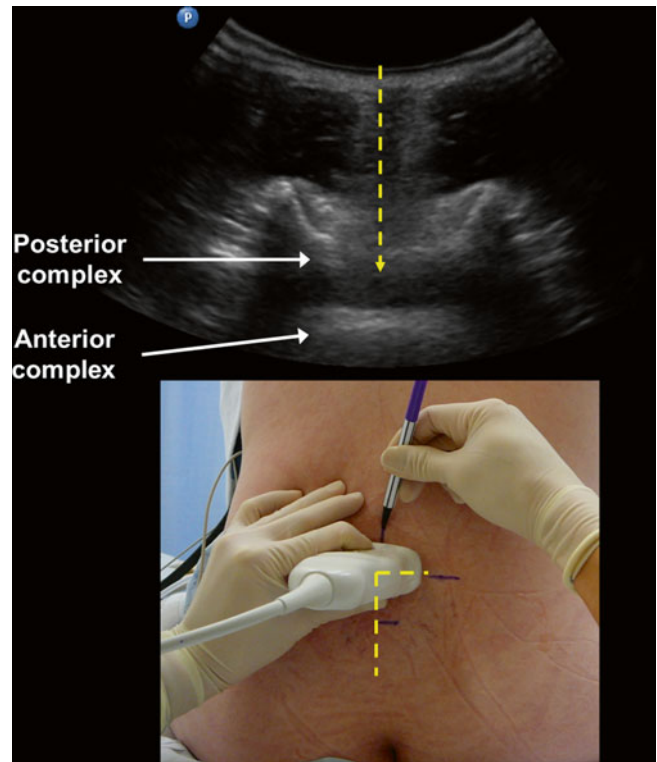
In the transverse midline interlaminar view, the midline is centered on the ultrasound screen, and skin marks are made at the midpoint of the probe’s long and short edges. The intersection of these two marks provides an appropriate needle insertion point for a midline approach to the epidural or intrathecal space at that level (Courtesy of www.usra.ca)
